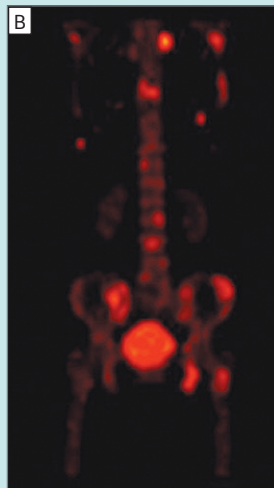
SPECT/CT helped localize multiple areas of abnormal uptake in several areas of the spine, pelvis and thoracic cage.
